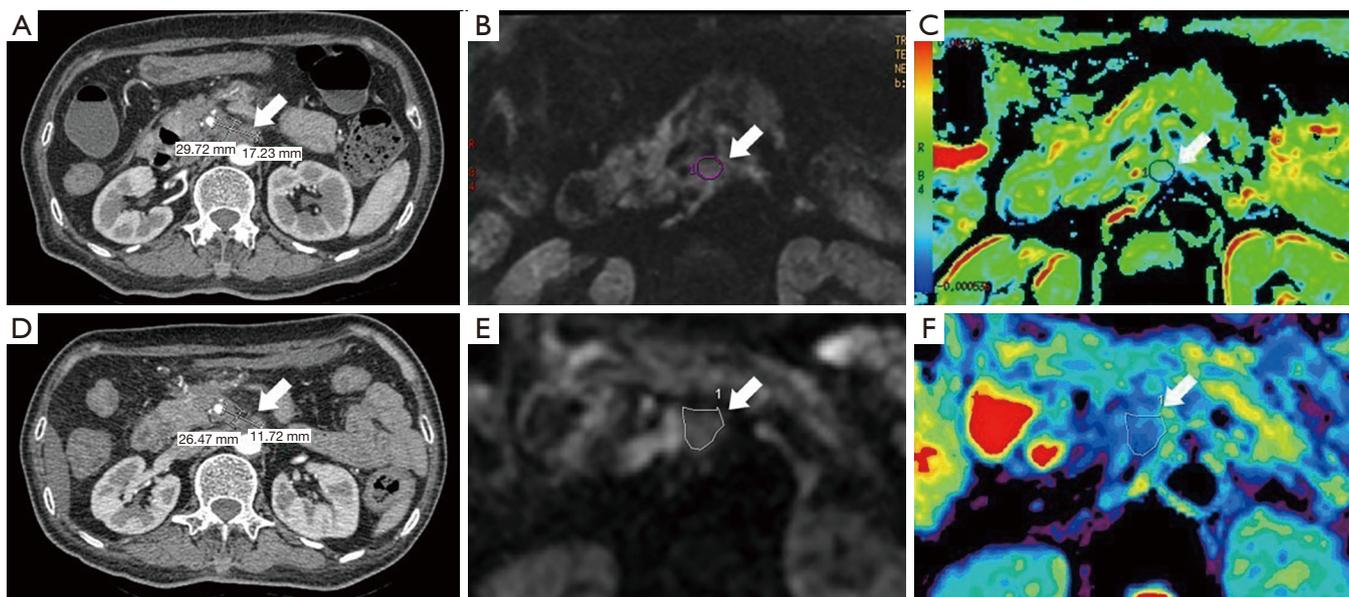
Images of case 3 indicate the change of the tumour after Endoscopic ultrasound (EUS)-radiofrequency ablation (RFA). (A) Computed tomography (CT) image of the pancreatic mass, which measured 29.7×17.2 mm prior to EUS-RFA; (B) magnetic resonance imaging diffusion-weighted imaging (MRI-DWI) (b-value 1,000 s/mm²) shows the ROI (region of interest, arrow) before therapy; (C) color-coded apparent diffusion coefficient (ADC) map of the pancreatic mass before therapy, and the tumour ADC is 997.0×10⁻⁶ mm²/s in the ROI (arrow); (D) a CT scan performed 1 month after EUS-RFA, showing that the size of pancreatic mass was 26.5×11.7 mm; (E) MRI-DWI (b-value 1,000 s/mm²) shows the ROI (arrow) after therapy; (F) color-coded ADC map of the pancreatic mass after therapy, and the tumour ADC is 1,397.3×10⁻⁶ mm²/s in the ROI (arrow).
